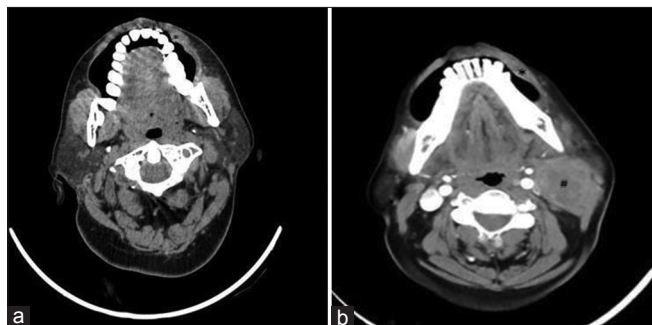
Axial plain (a) and contrast-enhanced computed tomography images (b) at the level of floor of mouth show an ulcerative soft-tissue density lesion (*) adjacent to the premolars on the left side. There is mild enhancement on post-contrast study. This lesion is seen extending into subcutaneous plane. There are few enlarged, enhancing conglomerated lymph nodes (#) with central non-enhancing areas in level II region on the left side
